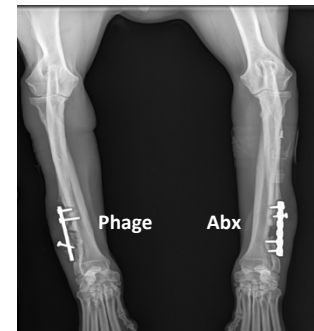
Figure – Endpoint Radiographs
